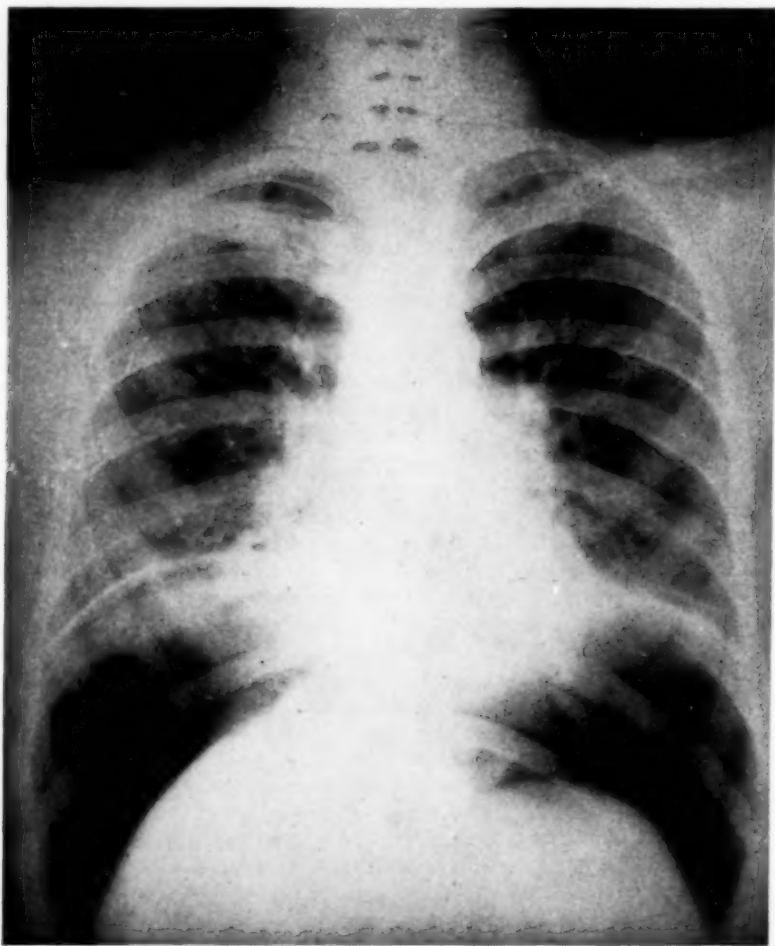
Roentgenogram of chest after pneumoperitoneum was established.
